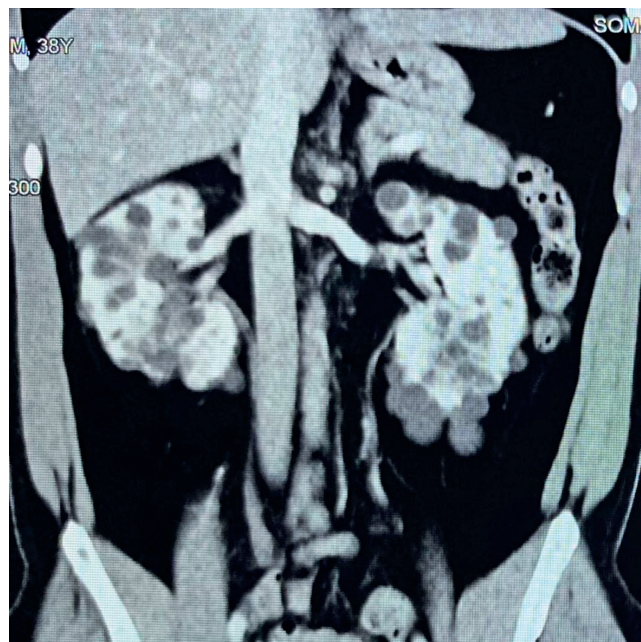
Computed tomography showing multiple kidney cysts bilaterally.
